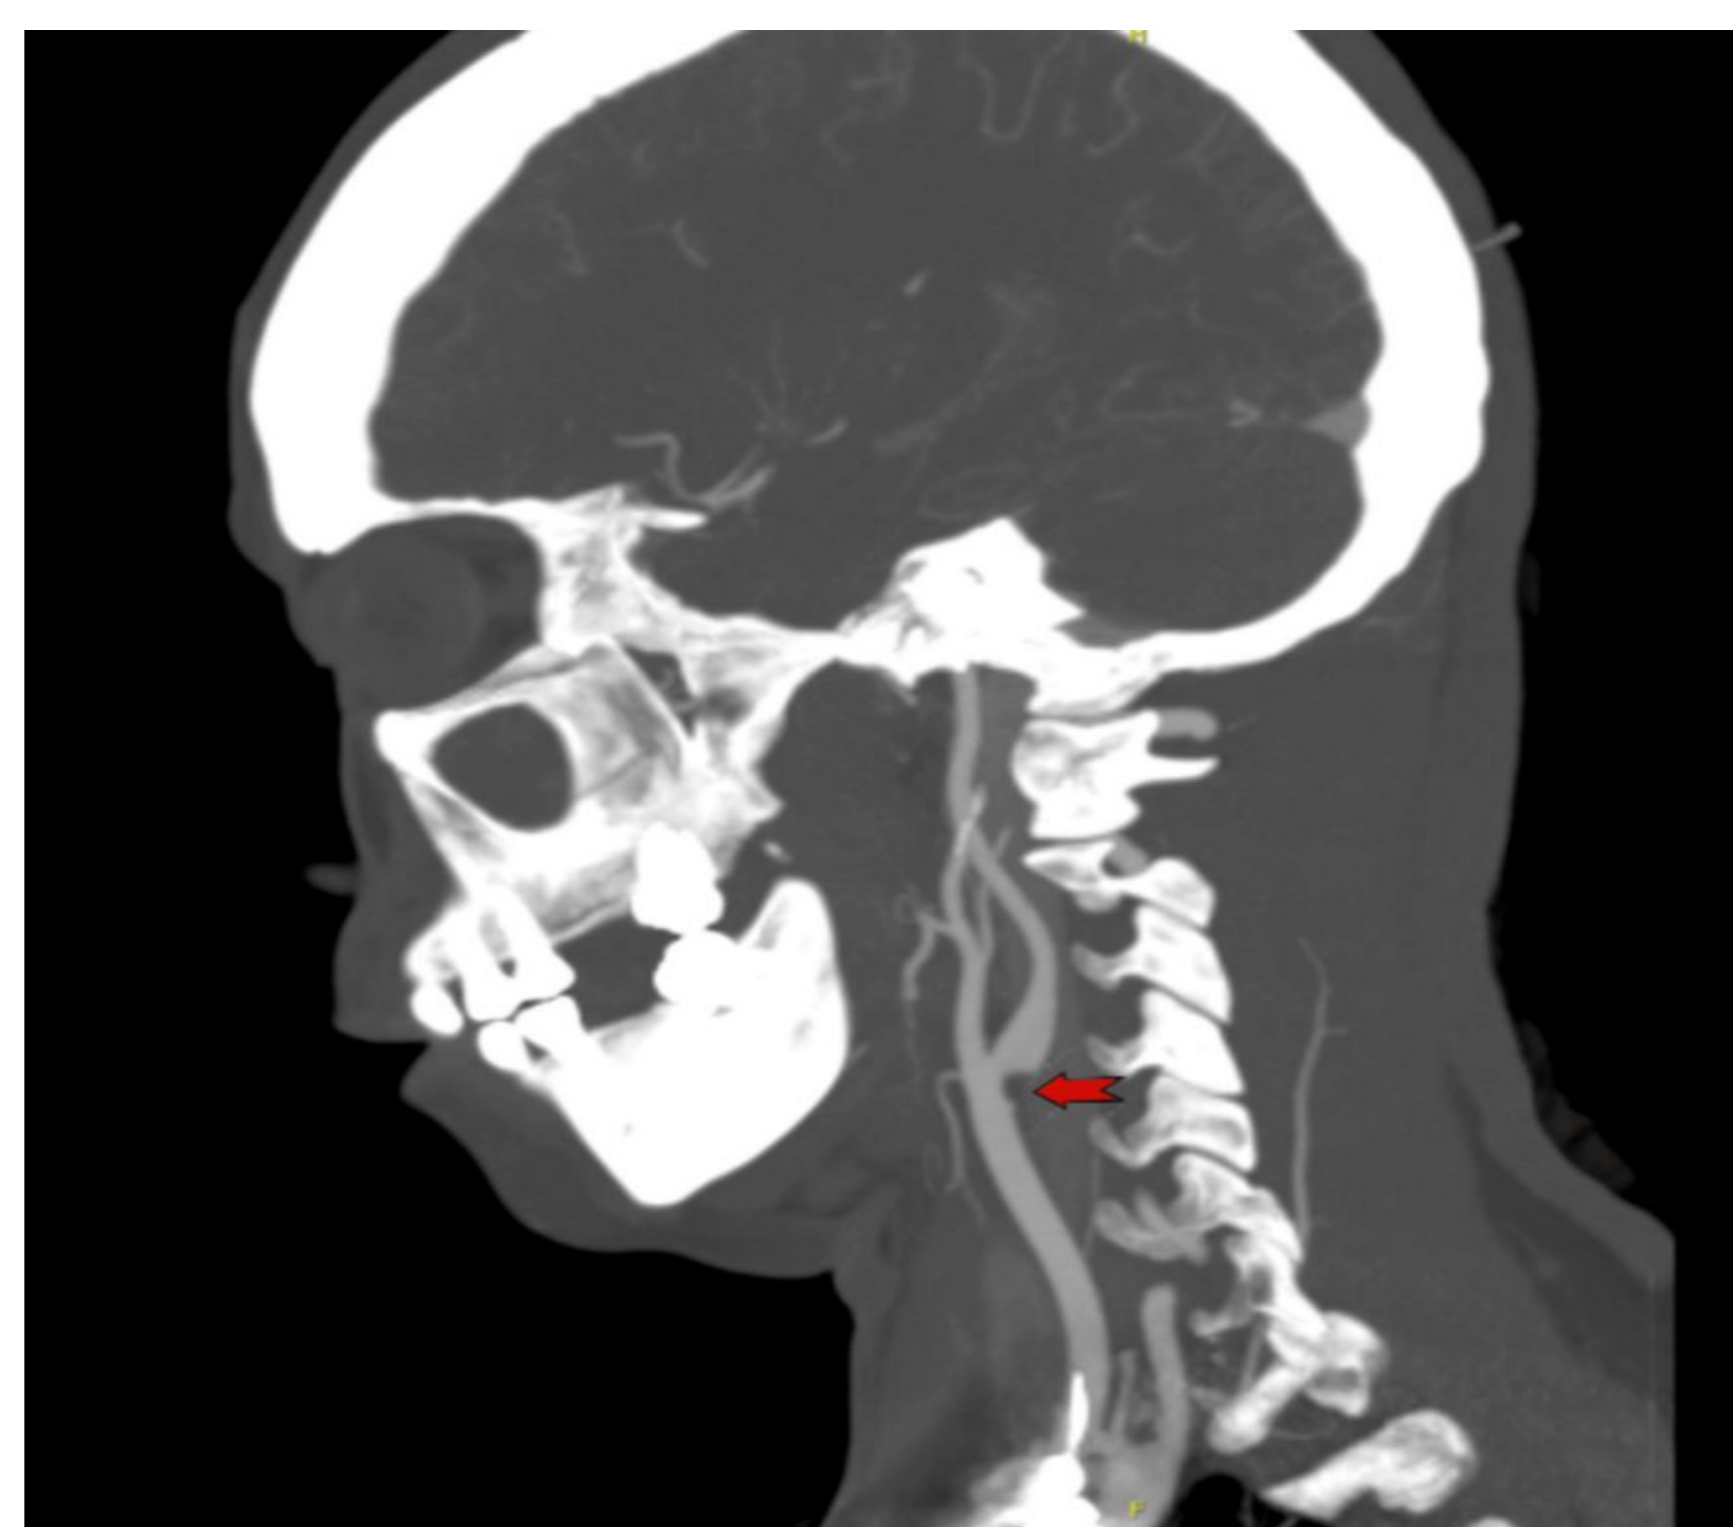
CT angiography (Sagittal view)
